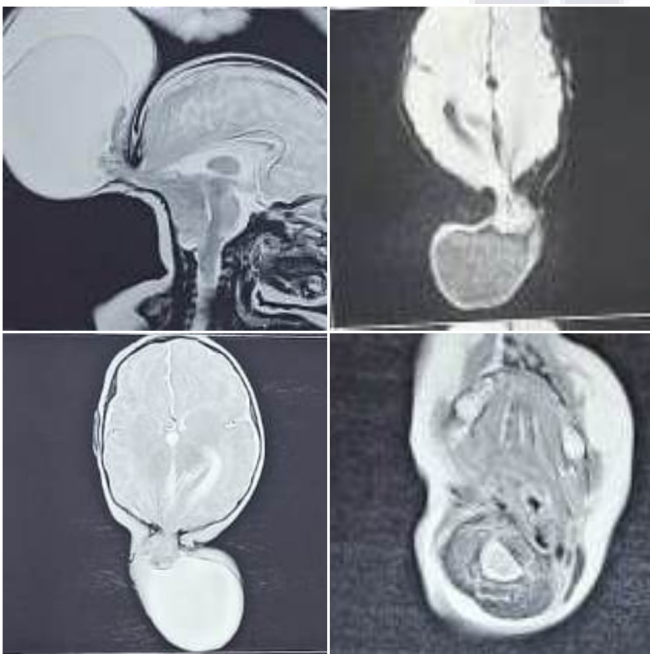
MRI Brain was suggestive of a well-defined T2 hyper intense T1 hypo intense outpouching with septations containing herniated bilateral occipital lobe, superior cerebellum.
